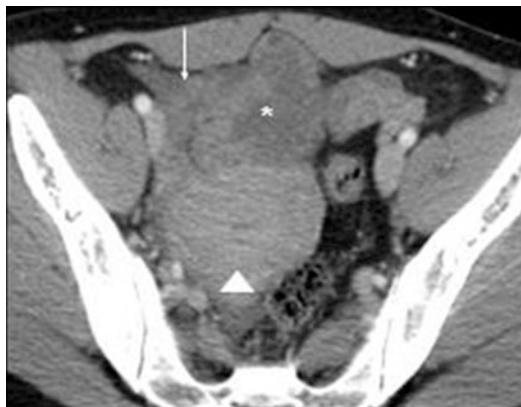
Ovarian torsion causing right lower quadrant pain. Axial upper pelvic CT image of a 26-year-old woman presenting with right lower quadrant abdominal pain shows an enlarged and edematous right ovary (asterisk) displaced to the midline, with peripheral distribution of the follicles, compatible with torsion. There is also ipsilateral uterine deviation (arrowhead) and hemorrhagic fluid (arrow) in the right lower quadrant anteriorly
